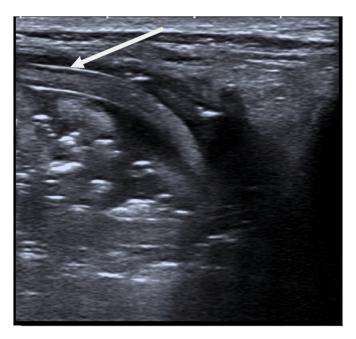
Multiple pairs of curvilinear echogenic lines were seen on abdominal ultrasonography (USG) within an adynamic, fluid-filled small intestine (Fig. 2).
